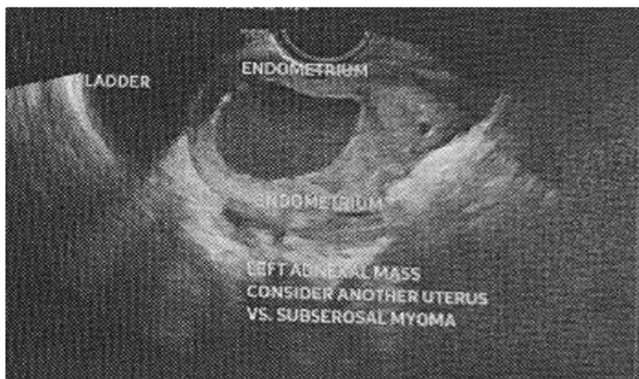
Transvaginal ultrasound showing a pelvic mass, probably a subserosal myoma with degeneration, measuring 67.5mm x 54.3mm x 50.5mm, with central dilation of 27.5 mm³ containing low level echoes and echogenic periphery.
